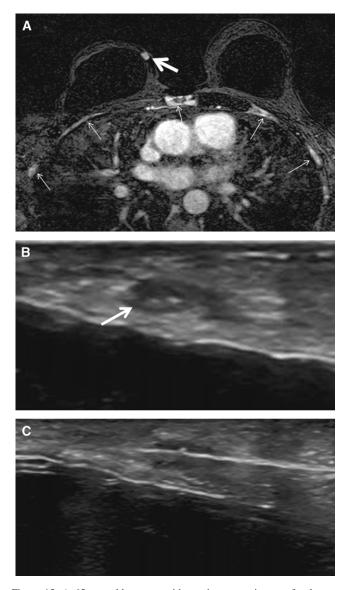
A 65-year-old woman with a primary carcinoma of unknown origin. (A) Magnetic resonance imaging, demonstrating a 6-mm enhancing mass in the right breast (thick arrow) on axial T1 subtracted image. Numerous bony metastases are evident in the thorax (thin arrows). (B) A second-look ultrasound (US) showed a small heterogenous lesion (arrow) overlying the right breast implant. There were minimal suspicious features. (C) A 14-gauge US-guided biopsy provided the diagnosis of invasive lobular carcinoma.
